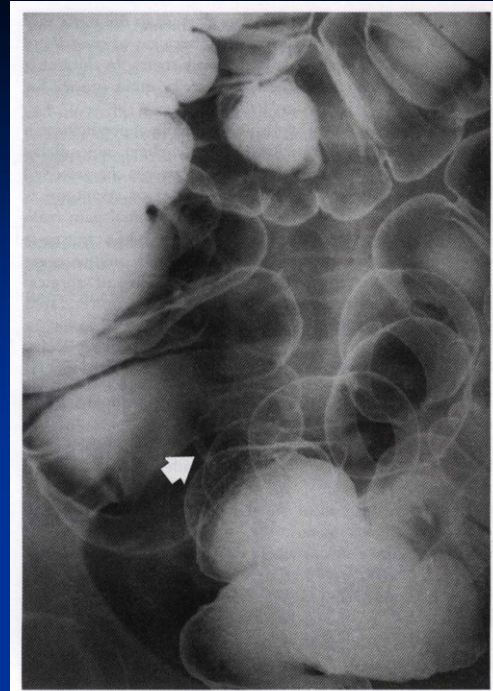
Barium enema radiograph demonstrating faecaliths of the appendix (arrow) with distal stricture of the appendix.
